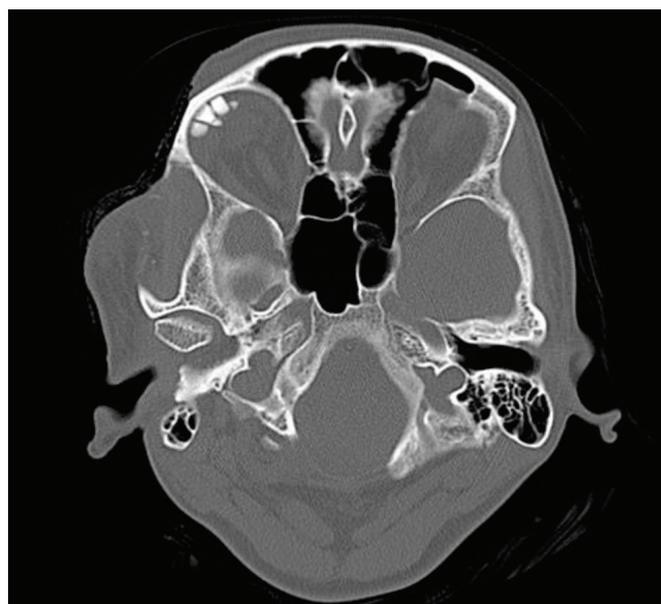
Computed tomographic scan of orbit (3 × 3 mm cut) showing four inert foreign bodies in the extraconal space right eye. Note the soft tissue swelling over the right temporal region
